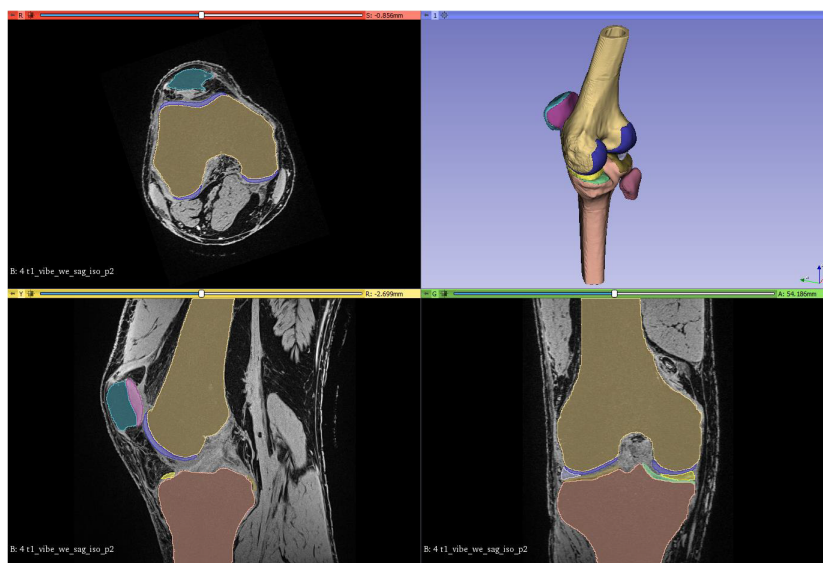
Knee segmentation from MRI scans (Adapted from Rao (2020))
